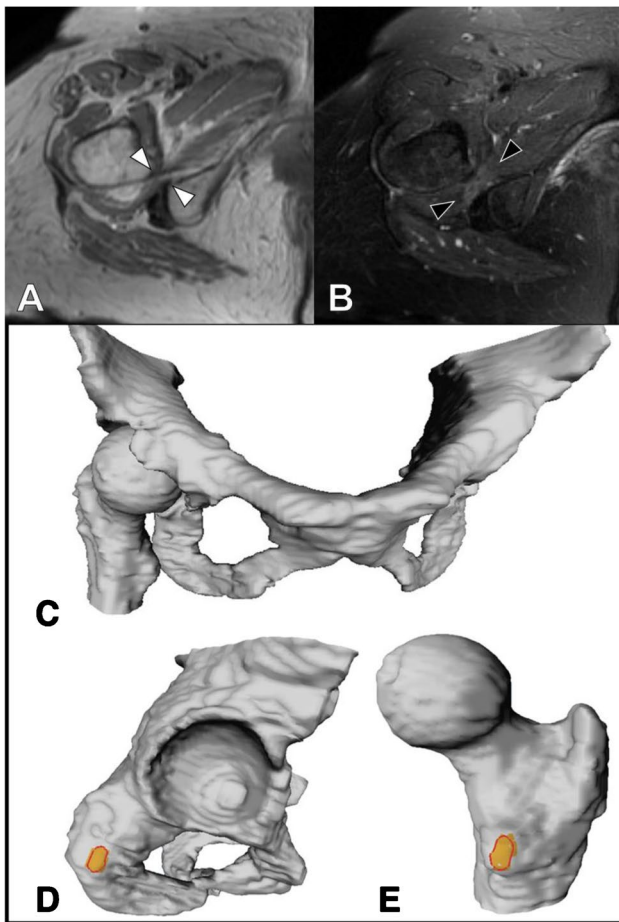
A Axial PD-weighted and B T2-fat suppressed MRI of a symptomatic ischiofemoral impingement hip showing narrowed ischiofemoral and quadratus femoris spaces (white arrowheads) and thinning of the quadratus femoris muscle (black arrowheads). Corresponding 3D models of the same patient showing overlaid impingement location (colored area): C pelvis with articulated hip at isolated maximal extension, D ischium, E proximal femur
